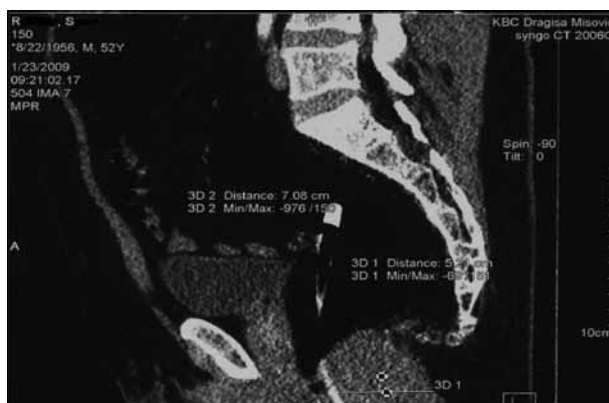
Computed tomography scanning of the small pelvis revealed circumferential rectal thickening (7.2 cm in length and 1.8 cm thickness) located 3.2 cm from the anus, leading to the narrowing of the rectal lumen with several enlarged perirectal nodes
